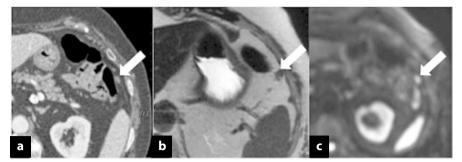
Axial computed tomography (CT) image showing (a) a solid nodule < 5 mm near the splenic flexure (*arrow*) suspected to be fibrotic tissue in a patient with sigmoid cancer (pT3N+) treated with surgical intervention and adjuvant chemotherapy 6 months earlier. b Axial T2-weighted magnetic resonance image (MRI) better depicts the small, solid nodule (*arrow*) due to the high-contrast resolution. c At diffusion-weighted imaging (DWI), the nodule shows hypercellularity and is strongly suspected to be a peritoneal metastasis
